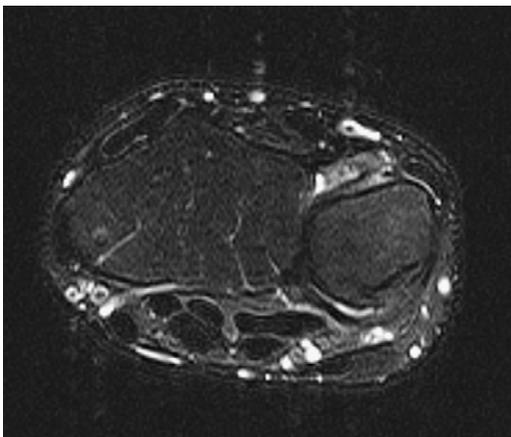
MRI of the wrist demonstrated a dorsal distal radioulnar ligament avulsion from the distal radius with an intact triangular fibrocartilage.
